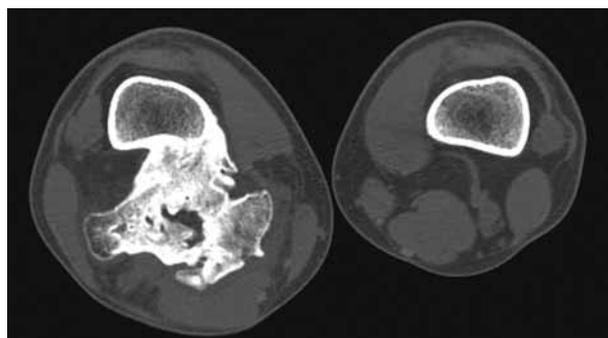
Computed tomography scanning demonstrated the bone pattern of mineralization within the mass and revealed a focal, sessile attachment of the mass to the adjacent femoral cortex.
